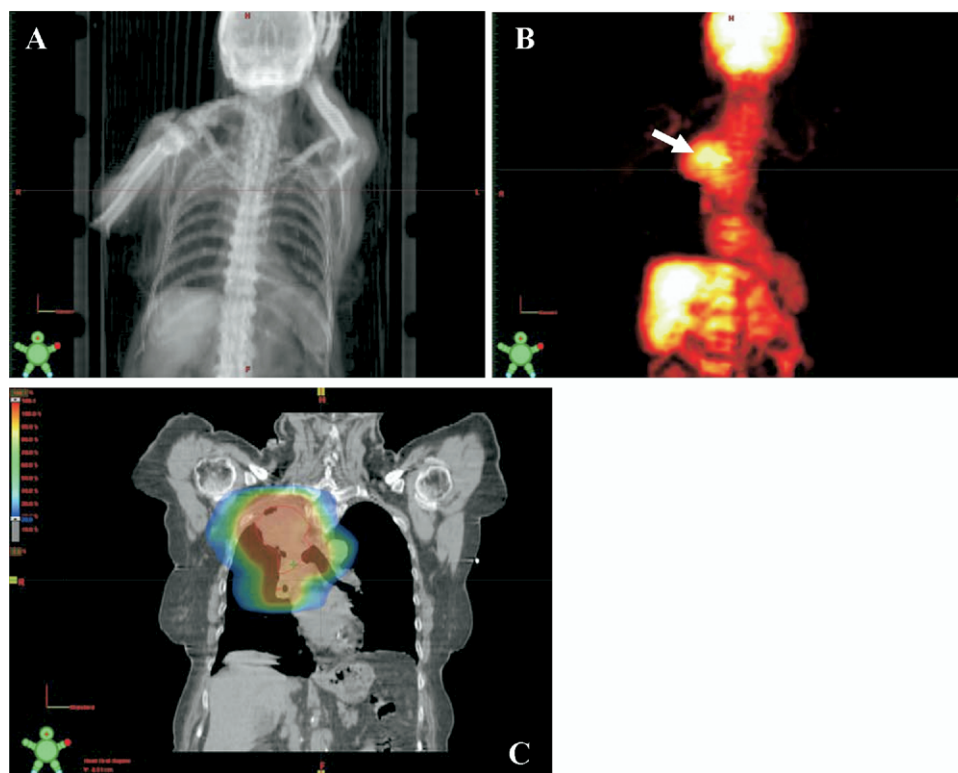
Target delineation of lung cancer by PET-CT in treatment planning. (A) Coronal view of CT image. (B) Intense uptake seen on PET image. Note that the both set of images were acquired in single PET/CT scan. (C) GTV delineation (red line) and isodose distribution (color wash). (Image courtesy of Montefiore Medical Center.)
